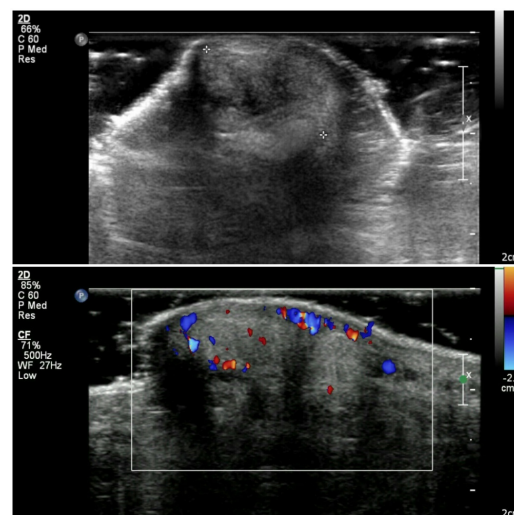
(a) Ultrasound, (b) Vascular Doppler study.
